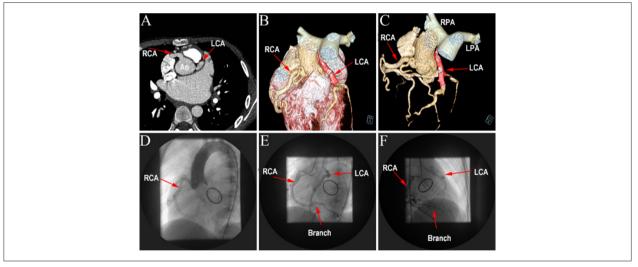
Computed tomography angiography scan image showed a giant RCA (A, B and C, arrows) and ALCARPA (C, arrows); Ascending aorta angiography only showed dilated and twisted RCA (D, arrows) and a phenomenon of stealing blood (E and F, arrows). Ao: aorta; RCA: right coronary artery; LCA: left coronary artery; LPA: left pulmonary artery; RPA: right pulmonary artery.
